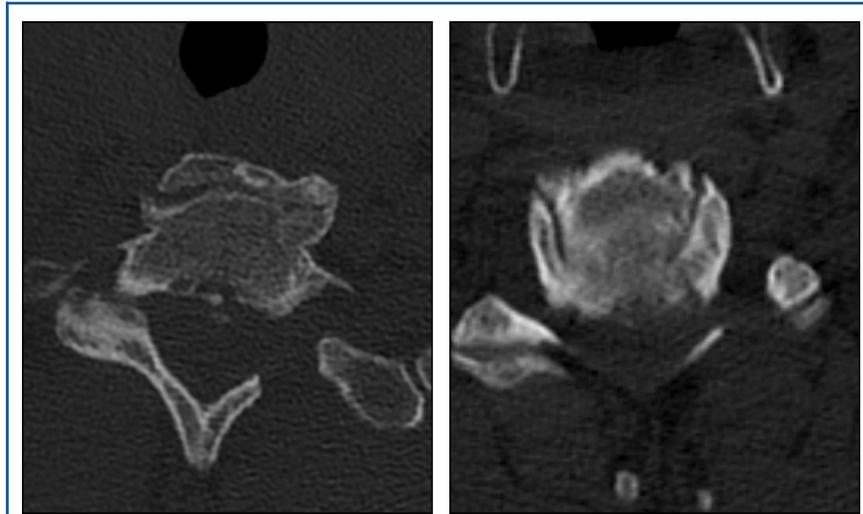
Axial CT after left foraminotomy showing the extent of bone drilling at C7/T1 (C8 root; left figure) and at C3/4 (C4 root; right figure).
